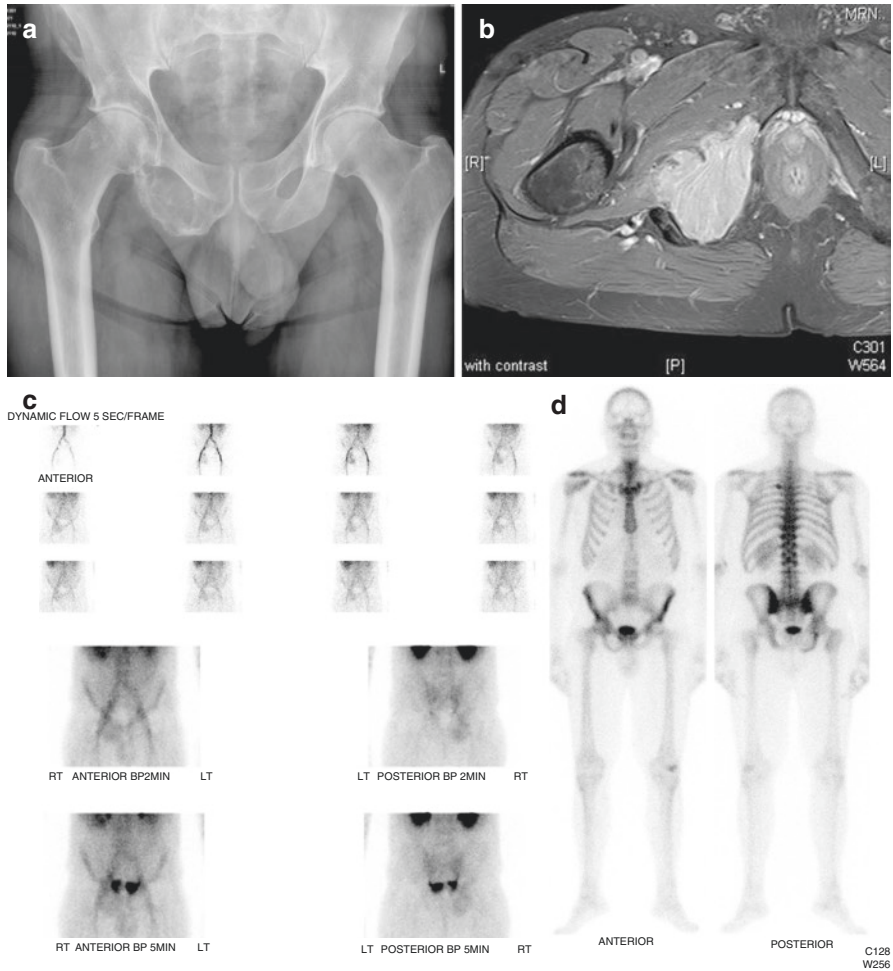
(a) Middle aged patient with an expansile lytic lesion involving the right inferior pubic ramus and ischium. (b) Axial contrast-enhanced T1 MRI image showing marked enhanced and loss of the cortical margins in keeping with an aggressive lesion. (c) Immediate limited dynamic and blood pool images following injection of Tc-99m MDP showing increased vascularity and blood pool activity of the lesion. (d) Delayed whole-body views demonstrate only very subtle asymmetry of the right inferior pubic ramus and ischium typical of multiple myeloma. Focal uptake involving the posterior left fifth rib corresponds to a fracture
